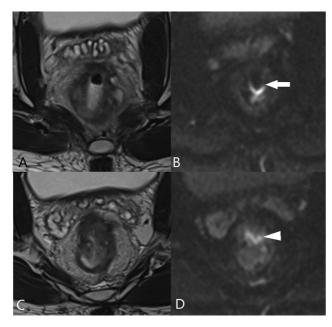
Susceptibility artifacts in diffusion-weighted imaging (DWI) due to air in the bowel lumen. (A, C) T2 high-resolution (HR) axial images show intraluminal air close to the bowel wall containing evident residual disease. (B, D) DWI (B800) shows susceptibility artifacts overlying the tumor-bearing rectal wall (arrow in B) and image distortion (arrowhead in D).
